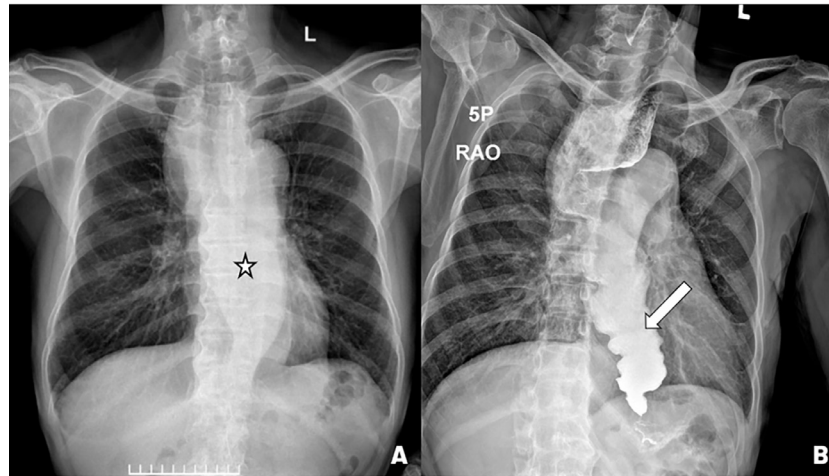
The frontal chest X-ray (A) showed a convex opacity (asterisk) overlapping the right mediastinum with an air-fluid level and bird beak sign (arrow) on the barium esophagogram (B).
